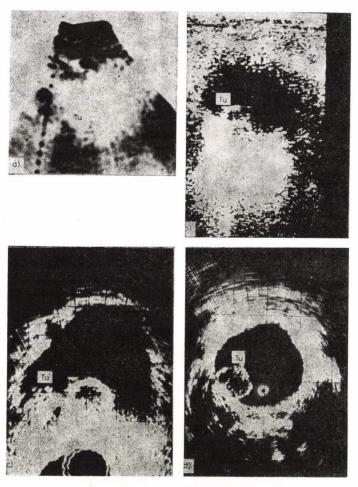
Ultrasonograms of tumour, the size of a nut, localized on the right side of the bladder. a. transabdominal Compound; b. transabdominal real-time transverse, section; c. transrectal; d. intravesical
